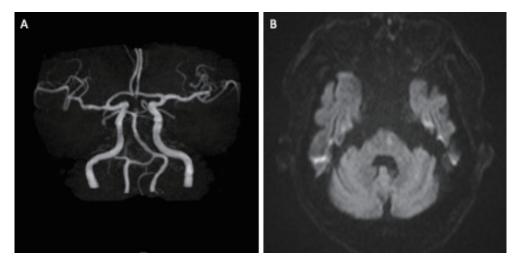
(A) (B) MRA and DWI on postoperative day 1 showed improved blood flow in the left VA and BA and no new infarcts.
